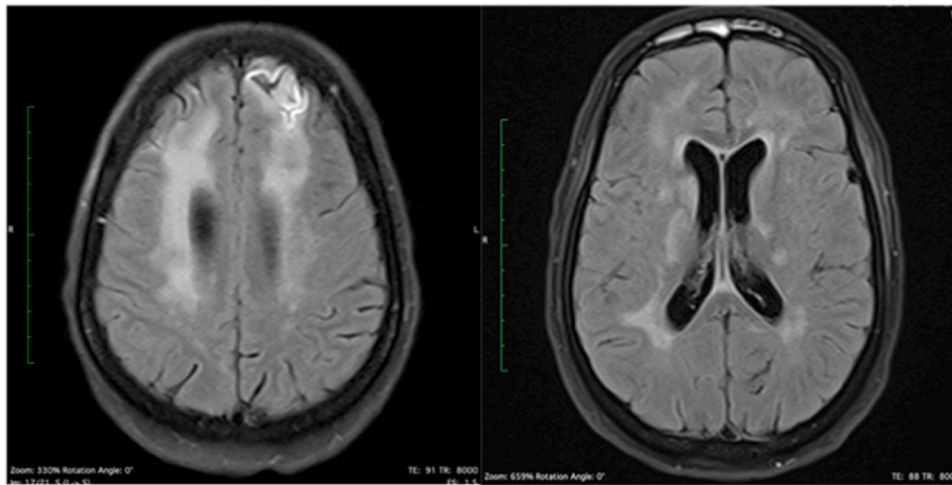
T2-weighted FLAIR sequence of brain MRI: Periventricular hyperintensity.
